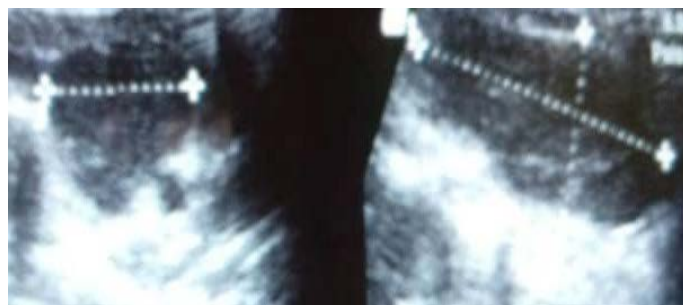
Cervical ultrasound in longitudinal section showing a 19 mm hypo-echoic supero-lobar nodule with limited contours higher than wide with multiple micro calcifications (Examination classified Ti-rads 5).
